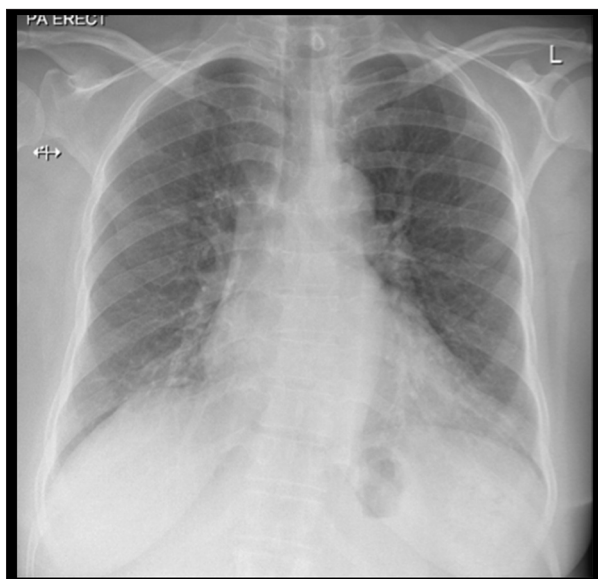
Posteroanterior erect chest radiograph 1 week before surgery showing no abnormalities.
